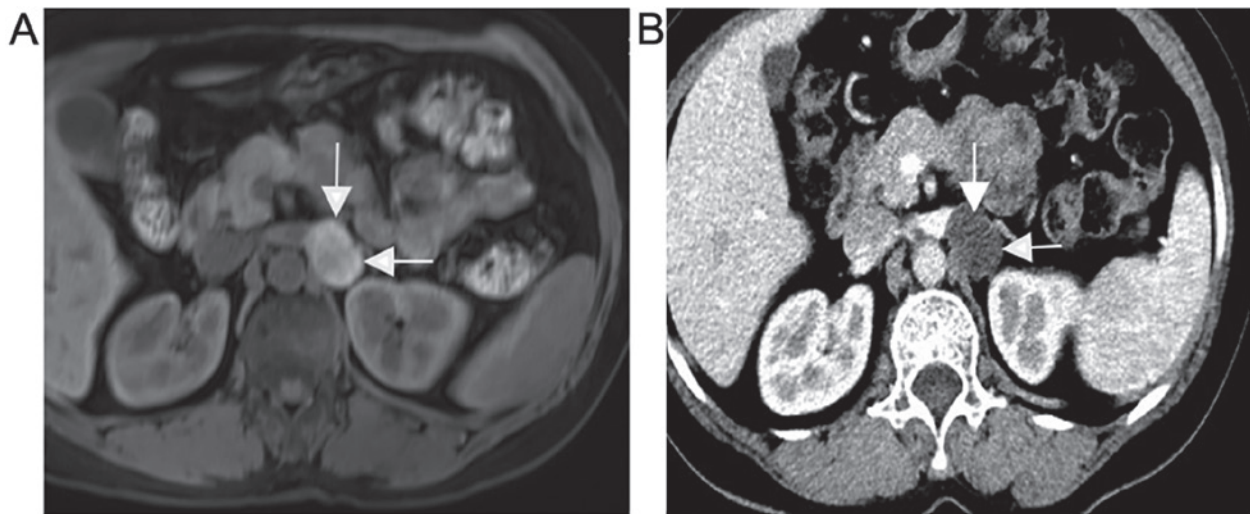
Imaging findings of the patient. (A) On T2 magnetic resonance imaging, the 25x19-mm mass (arrows) appeared as a nodular, irregular and long T2 signal shadow in the inferior margin of the left adrenal gland, slightly enhanced on contrast-enhanced imaging, suggesting a neurogenic tumor. (B) Enhanced computed tomography revealed a space-occupying lesion (sized ~28x20x33 mm) in the inferior margin of the left adrenal gland (arrows).
